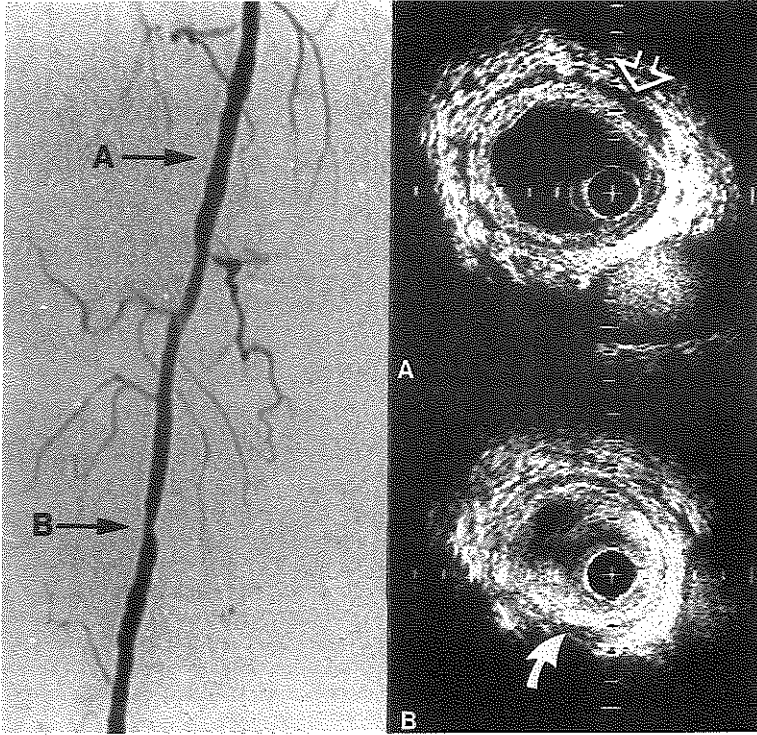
Angiogram reveals a 50% stenosis of the right superficial femoral artery. Intravascular ultrasound images (A,B) are from the positions indicated in the angiogram. Proximally a large lumen is imaged with diffuse intimal thickening (1 mm). The dark layer corresponds with the media (open arrow). The femoral vein is noted at 5 o'clock. At the level of stenosis (B) the medial layer is visible between 11 and 6 o'clock. Evidence of calcium deposition causing shadowing is seen at 7 o'clock (solid arrow). Calibration markers are 1 mm.
